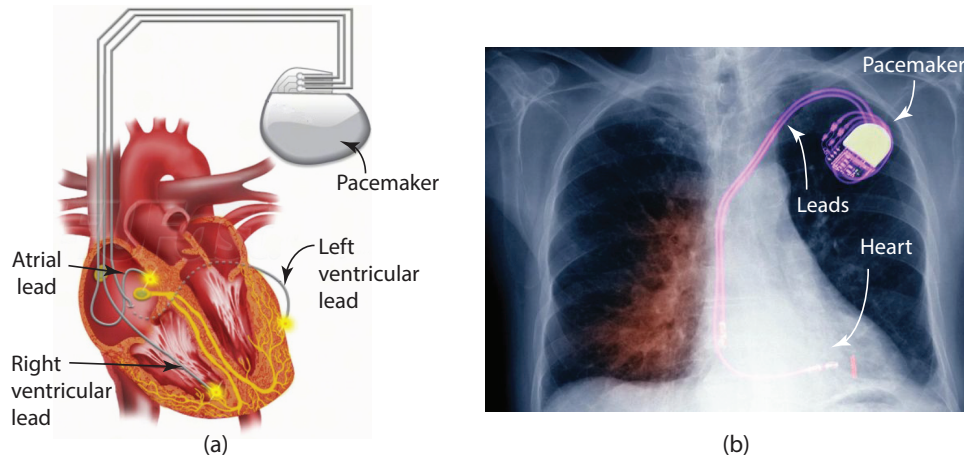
(a) A human's heart model showing complete pacing system, i.e., the pacemaker, leads and electrodes in atrial, right and left ventricles. (b) A chest X-ray after the implantation of a dual-chamber cardiac pacemaker [8].
